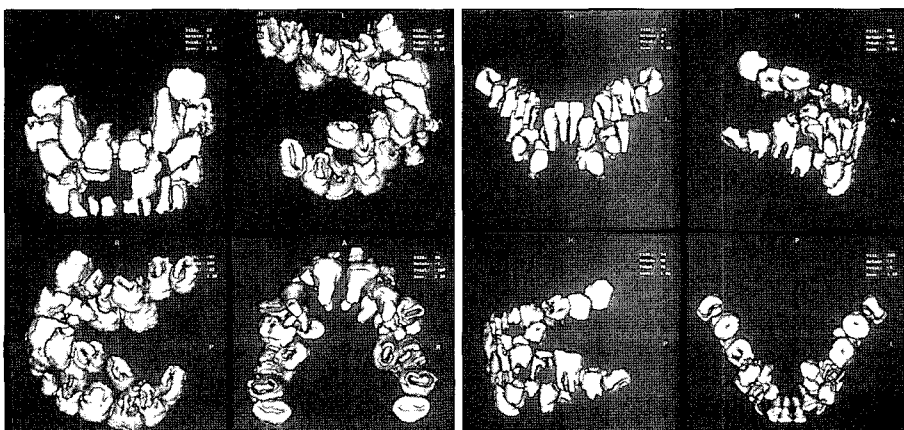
Reformatted 3D CT images of teeth shows supernumerary teeth in both jaws.
